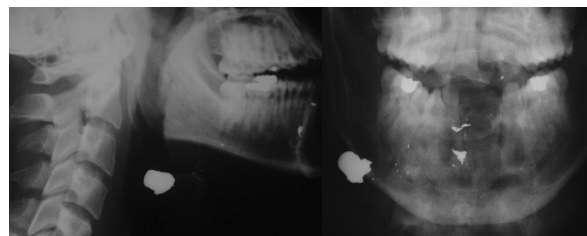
Patients initial radiographic image showing the bullet inserted in the mandible angle.
